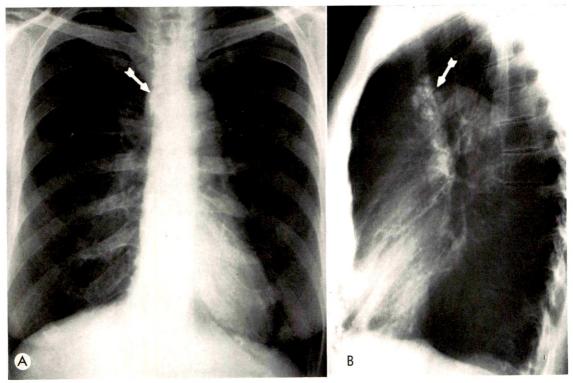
Case III. (A) Frontal teleroentgenogram of the chest showing the partially calcified 2×3 cm. mass in the right superior mediastinum (arrow). (B) Lateral roentgenogram shows the partially calcified superior middle mediastinum mass to advantage (arrow).
